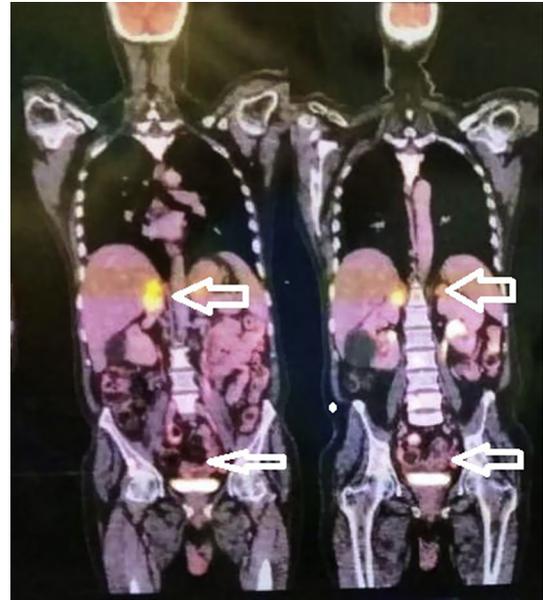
Arrows in PET CT indicating FDG-avid uptake in the liver, adrenals, and spine. PET CT, positron emission tomography computed tomography.
